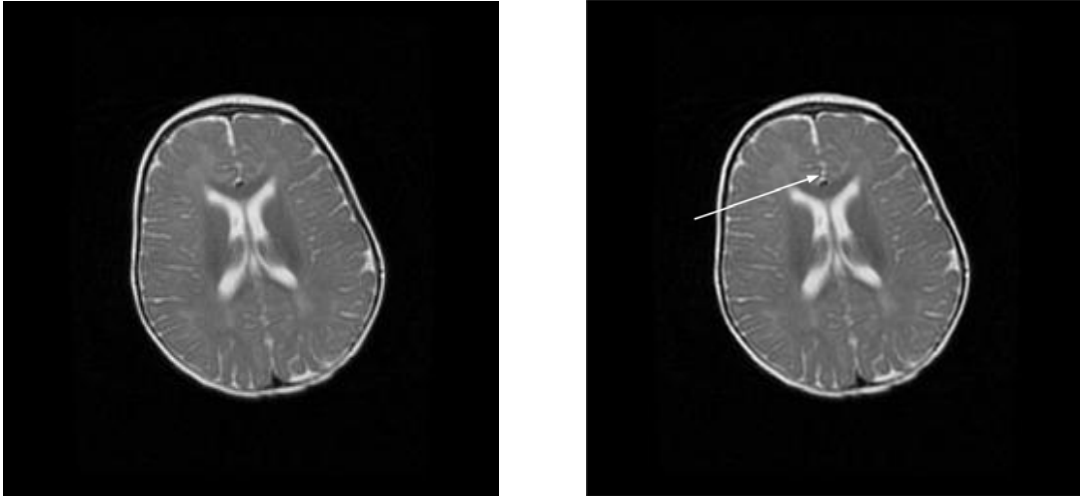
(a) a brain MR image; (b) same MR image with an artificial lesion inserted (arrow)
